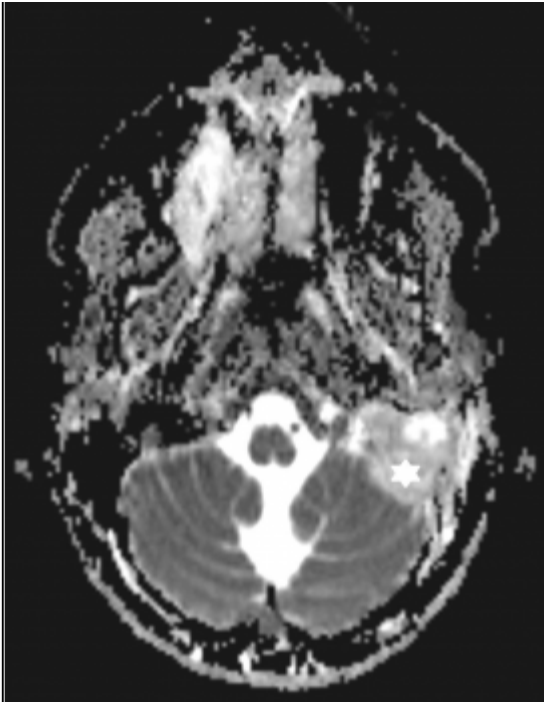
Axial DWI (A) and ADC maps (B)
